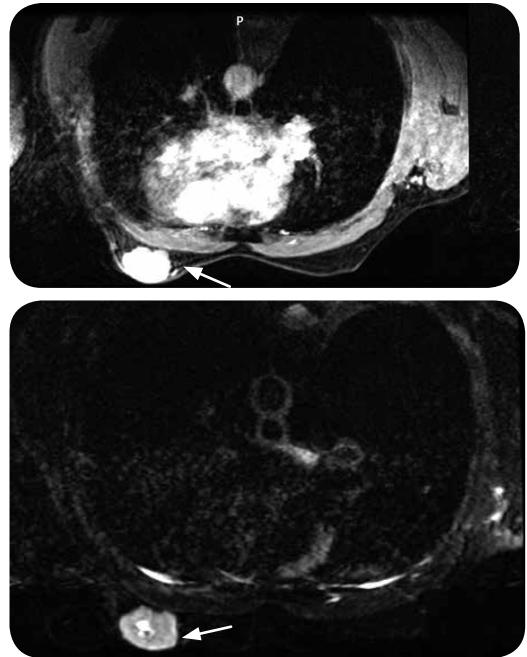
MRI: Retroareolar nodular image in the left breast of high signal with information T1 and T2 (arrows).
